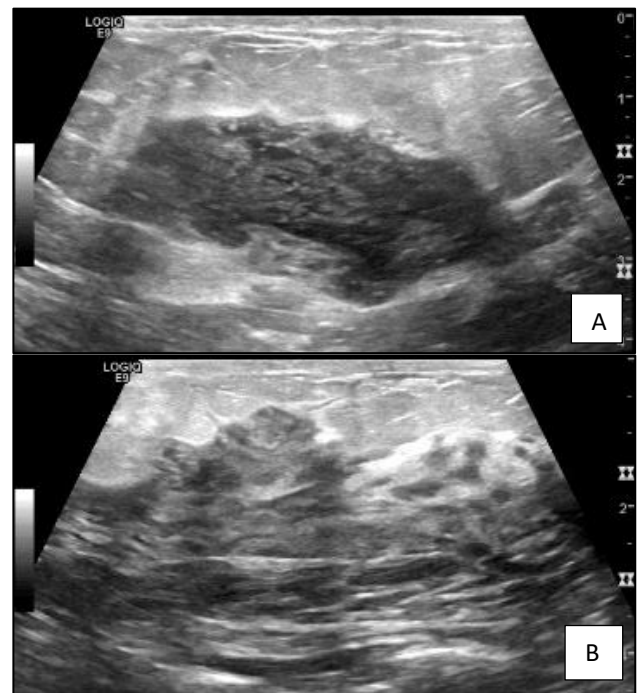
(A and B) Ultrasound findings of complex collections with appearances consistent with history of IGM.
